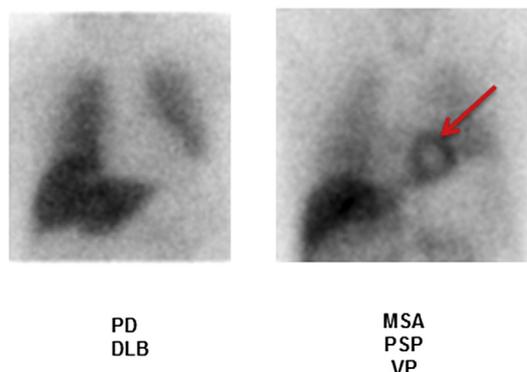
SPECT [ $^{123}\text{I}$ ]-MIBG measuring postganglionic sympathetic innervation in parkinsonian syndromes. A: reduced heart/mediastinum uptake ratio in Parkinson's disease (PD) and dementia with Lewy bodies (DLB); B: normal heart/mediastinum uptake ratio in multiple system atrophy (MSA), progressive supranuclear palsy (PSP) and vascular parkinsonism (VP).
